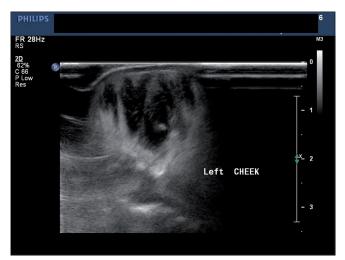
Ultrasonography left cheek
